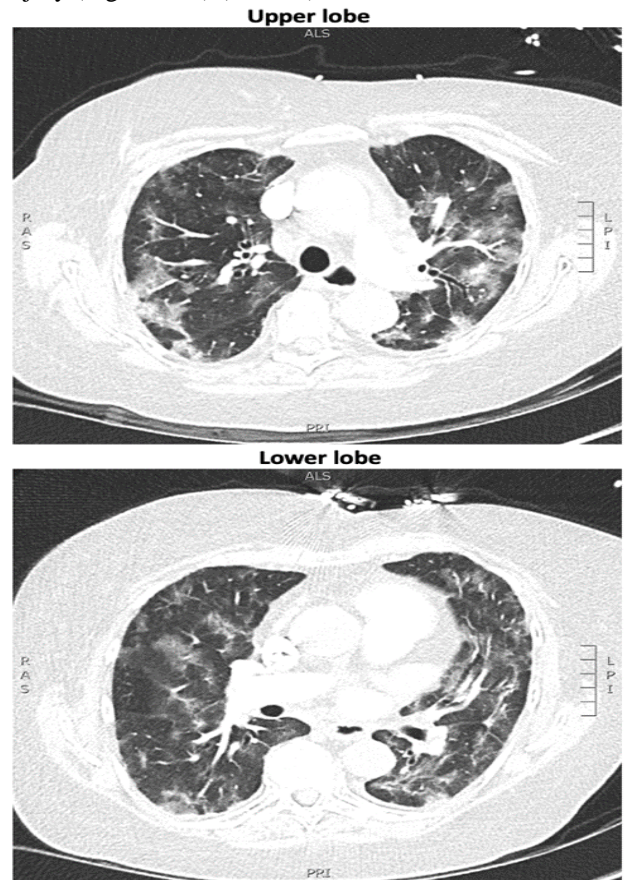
CT pulmonary angiogram (January 2025) showing bilateral lower zone ground-glass opacities and reticular changes.
